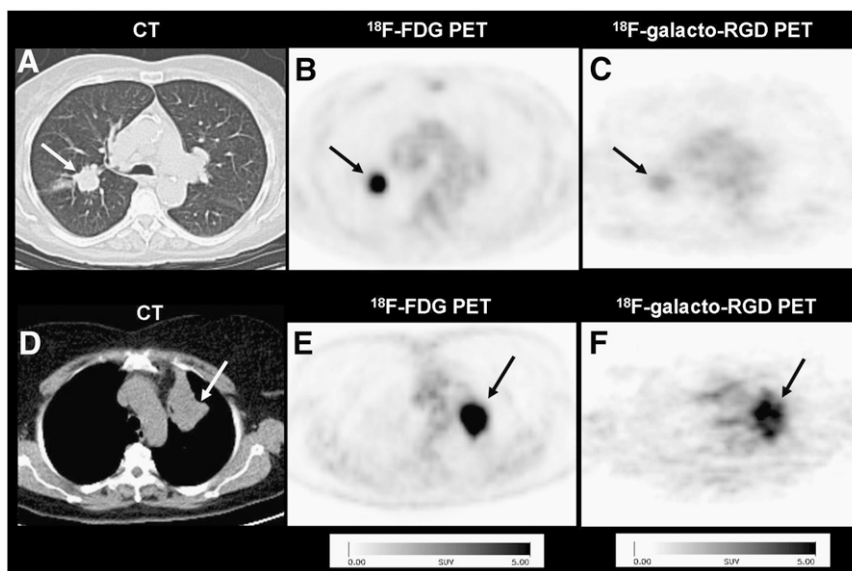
Comparison of patients with NSCLC of right lung (A–C) and left lung (D–F; arrows). Note intense uptake in both lesions in ^{18}F -FDG PET (B and E), whereas lesions demonstrate completely different uptake patterns in corresponding ^{18}F -galacto-RGD PET: There is only weak uptake in first patient (C), whereas there is intense uptake in second patient (F).
